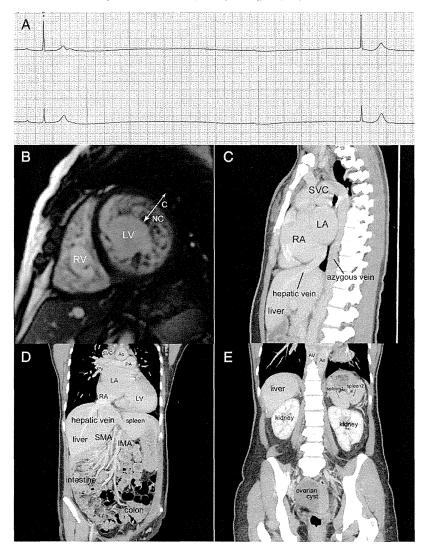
Characteristics of heterotaxy syndrome, left isomerism. A) A representative trace demonstrating sick sinus syndrome by the Holter monitoring showed the maximum long pause of 7.4 s, which was the duration from sinus arrest to subsequent junctional escape beat, that was recorded during sleep, although the patient showed no relevant symptoms of this finding. Standard calibration and paper speed in both records was 10 small boxes/m and 25 small boxes/s, respectively. B) Left ventricular (LV) end-diastolic apical short-axis view by cardiac magnetic resonance imaging showed a coarse and hypertrabeculated non-compacted left ventricle with a 2.8 NC/C ratio (double arrows). NC: non-compacted layer, C) Sagittal view by computed tomography (CT) showing the dilated azygous vein mimicking the aortic arch draining into the right superior vena cava (SVC). The hepatic vein directly returned into the right atrium. RA: right atrium, LA: left atrium. D) Coronal view by CT showing the intestinal malrotation by which the small bowel loops became located on the right side of the abdomen, and the colon became positioned on the left side. Ao: aorta, PA: pulmonary artery, PV: pulmonary vein, SMA: superior mesenteric artery, IMA: inferior mesenteric artery. E) Coronal view showing the accessory spleens. AV: azygous vein.
